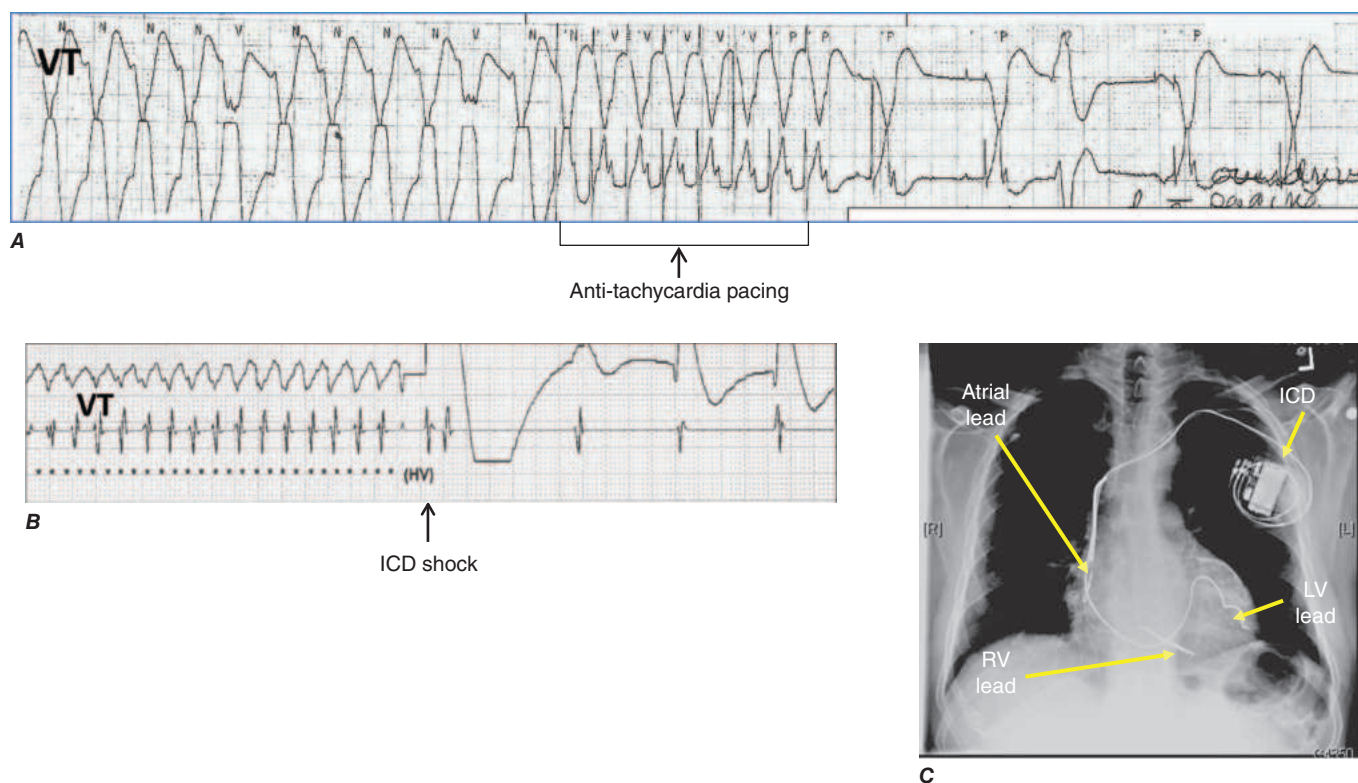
Implantable cardioverter-defibrillator (ICD) and therapies for ventricular arrhythmias. A. A monomorphic ventricular tachycardia (VT) is terminated by a burst of pacing impulses at a rate faster than VT (antitachycardia pacing). B. A rapid VT is converted with a high-voltage shock (arrow). The chest x-ray in the panel C shows the components of an ICD capable of biventricular pacing (yellow arrows). ICD generator in the subcutaneous tissue of the left upper chest, pacing leads in the right atrium and the left ventricular (LV) branch of the coronary sinus (LV lead), and a pacing/defibrillating lead in the right ventricle (RV lead) are shown.
